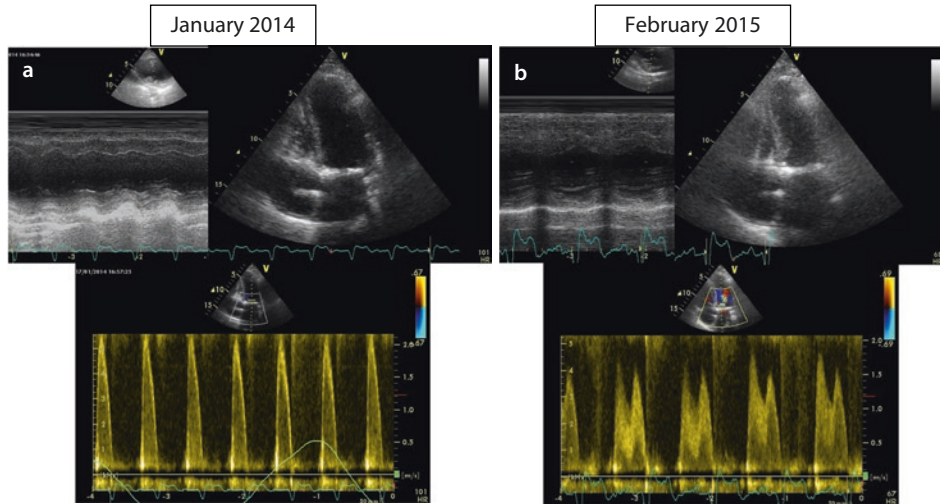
Female patient, treated by mediastinal radiotherapy in 1981, at age 24, for Hodgkin lymphoma. In the following years, she had: thyroidectomy for cancer (2000); acute myocardial infarction (inferior wall and right ventricle) with 95% ostial stenosis of the right coronary artery (2008) treated with angioplasty; recurring pneumonia; complete atrioventricular block treated by pacemaker (2012); transcatheter aortic valve replacement for severe stenosis (2013); occlusion of the right coronary artery (2013). (a) Systolic four-chamber view, ventricular M-Mode, and diastolic mitral Doppler flow in January 2014: an extensive calcification of the mitral annulus is evident; heart rate 101, ejection fraction 57%, and restrictive pattern at Doppler. (b) One year later, after adding to therapy bisoprolol 2.5 mg and Ivabradine 10 mg the heart rate is reduced to 68, the ejection fraction increased to 62%, mitral flow has improved, and symptoms have improved from NYHA 3 to NYHA 2
